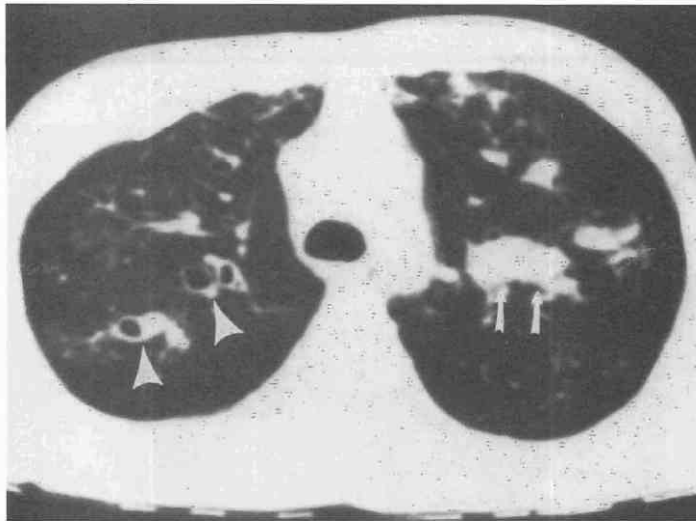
CT signs of bronchiectasis. The signet ring sign (*arrowheads*) consists of the dilated bronchus (the ring) and its accompanying pulmonary artery (the signet). A large mucous plug fills one of the dilated bronchi (*arrows*). (From Kuhlman JE, Reyes BL, Hruban RH, et al: Abnormal air spaces in the lung. *Radiographics* 13:47-75, 1993.)
